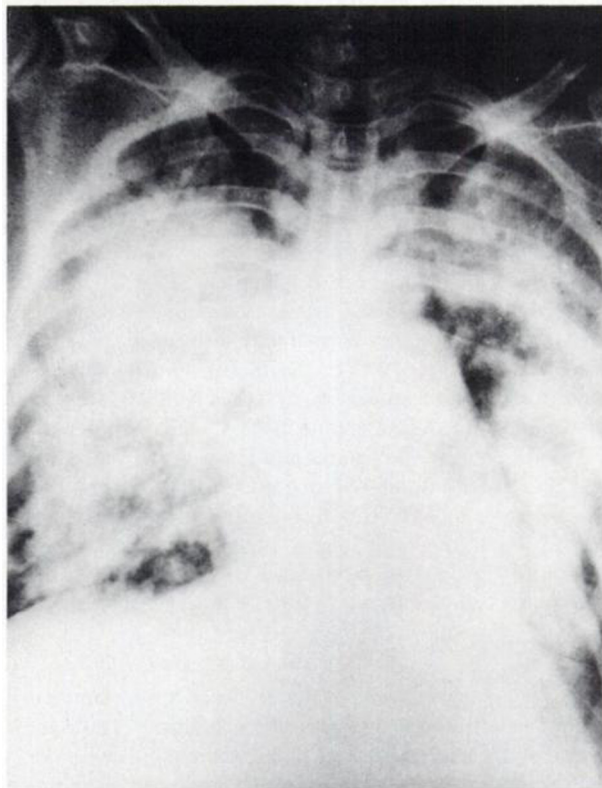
Portable chest roentgenogram, at the time of admission, showing severe bilateral pulmonary edema.
